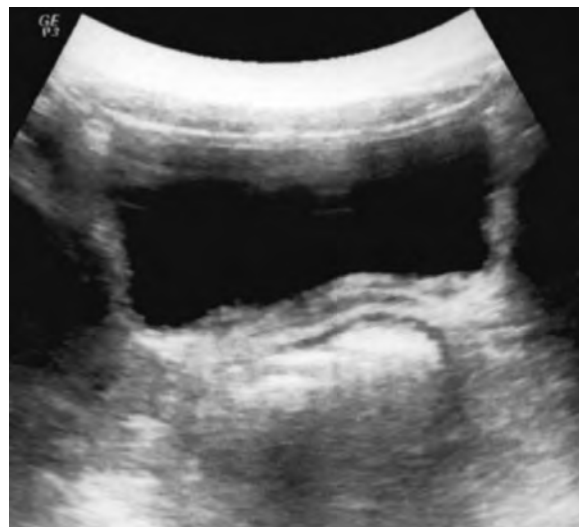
Pelvic ultrasound demonstrating a thickened bladder wall and a large amount of stool in the rectum.
